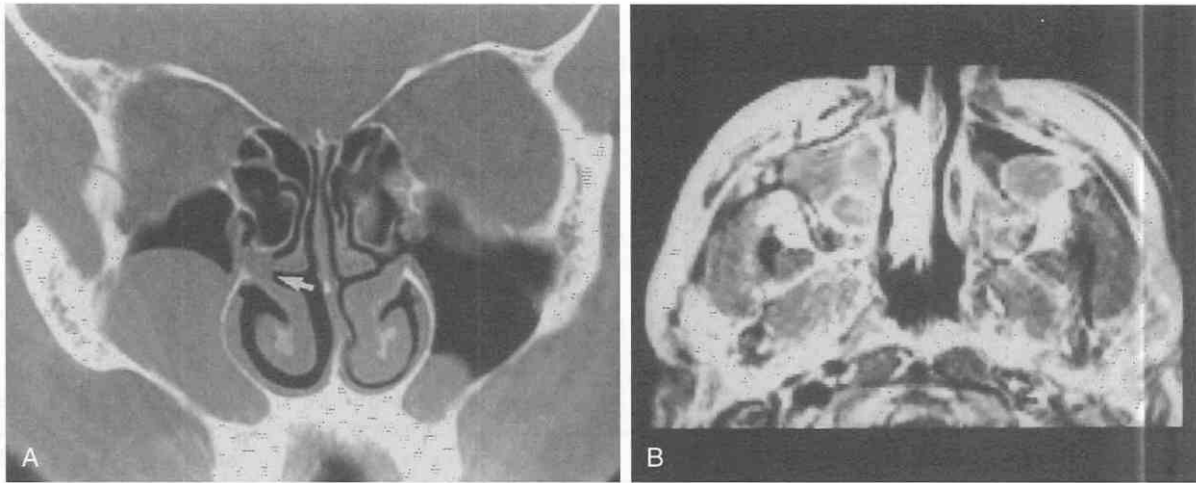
Nasal polyps. Retention cysts and nasal polyps are indistinguishable on CT scans and MRI studies. Rounded, soft tissue density structures within the maxillary sinuses on the CT scan (A) represent retention cysts or polyps when there is no bone destruction or expansion. These are usually asymptomatic; however, when they occur near the orifices of sinuses such as in the infundibulum (arrow), postobstructive changes in the corresponding ostiomeatal unit may occur. On MRI examination following contrast injection (B), there is linear enhancement on the surface of most polyps and retention cysts. This helps to distinguish them from solid masses.
